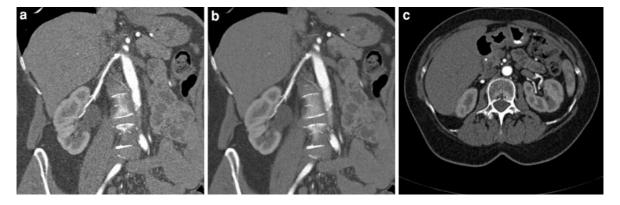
CT images of renal arteries obtained at 100 kVp and 87 effective mAs with AEC in a renal donor with a BMI of 20.0 kg/m² and an abdominal diameter of 30 cm (CTDIvol: 3.90 mGy; DLP:127 mGy cm). a 0.75 mm coronal oblique CT
